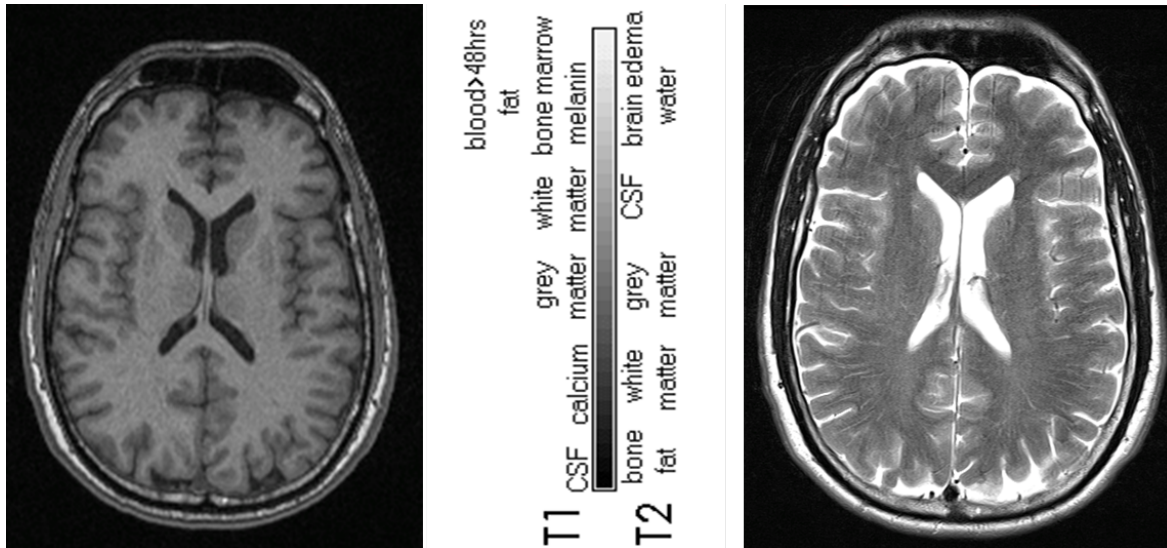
Axial slices of T1-weighted (left) and T2-weighted (right) images and grey map distribution of brain tissue (in the middle).
